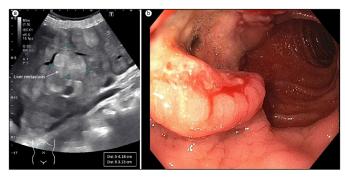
(a) Abdominal ultrasonography showing gallbladder distention and an enlarged liver with diffuse infiltration with numerous low-density echogenic mass suggestive of metastasis. (b) Esophagogastroduodenoscopy revealing a normal esophagus and a large fungating infiltrative ulcerated mass involving the gastric antrum and pylorus.
